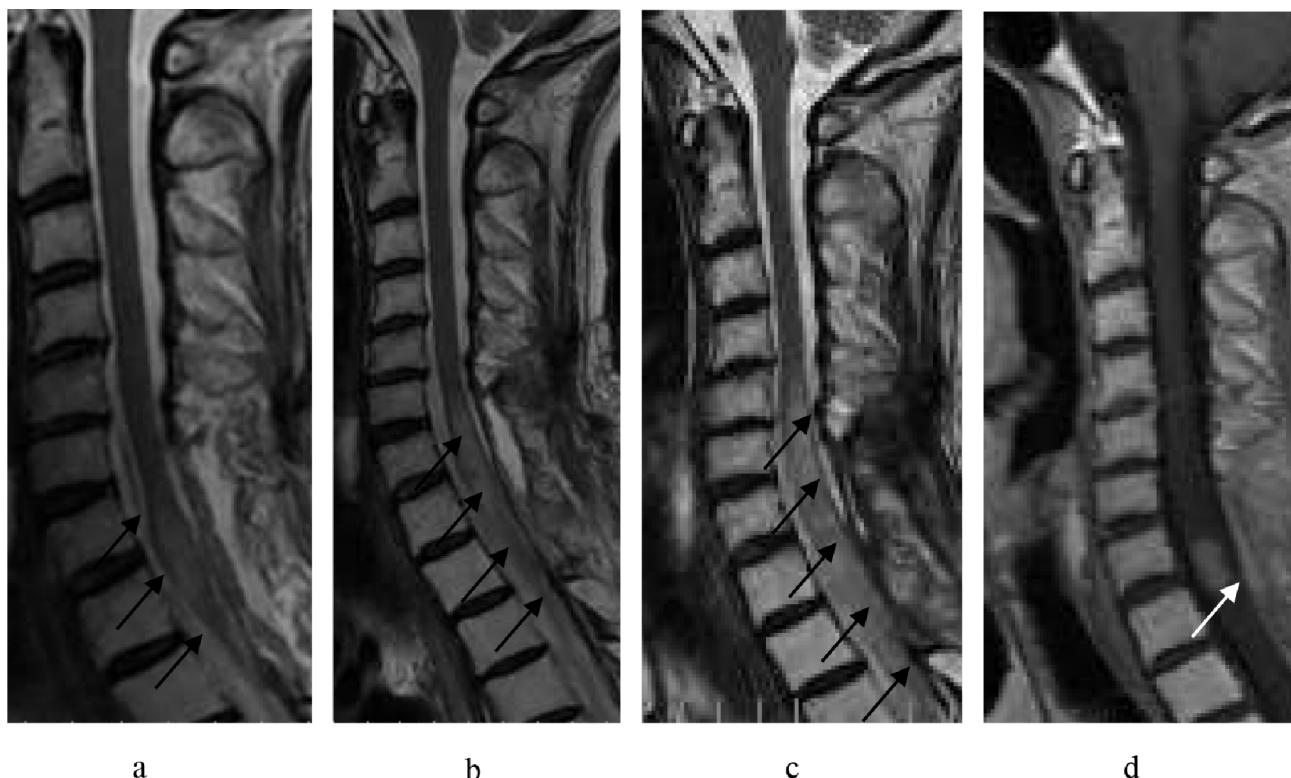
(a–d) Postoperative MRI findings (a) MRI on postoperative day 7, (b) MRI on postoperative day 25, and (c, d) MRI on postoperative day 57. (d) Contrast-enhanced MRI. Progressive spinal cord edema
